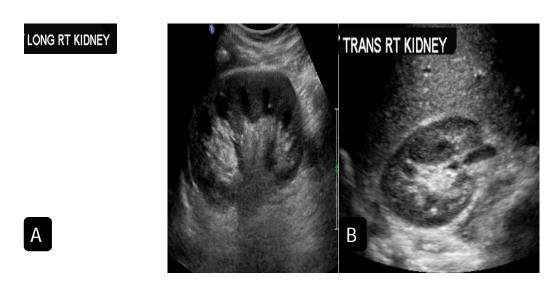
Normal kidney. Longitudinal (A) and transverse (B) gray-scale sonogram.(from www.springerlink.com.2006)
